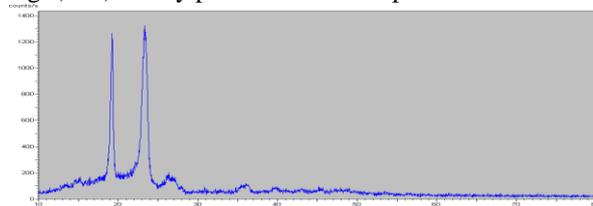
X-ray patterns of nimodipine
